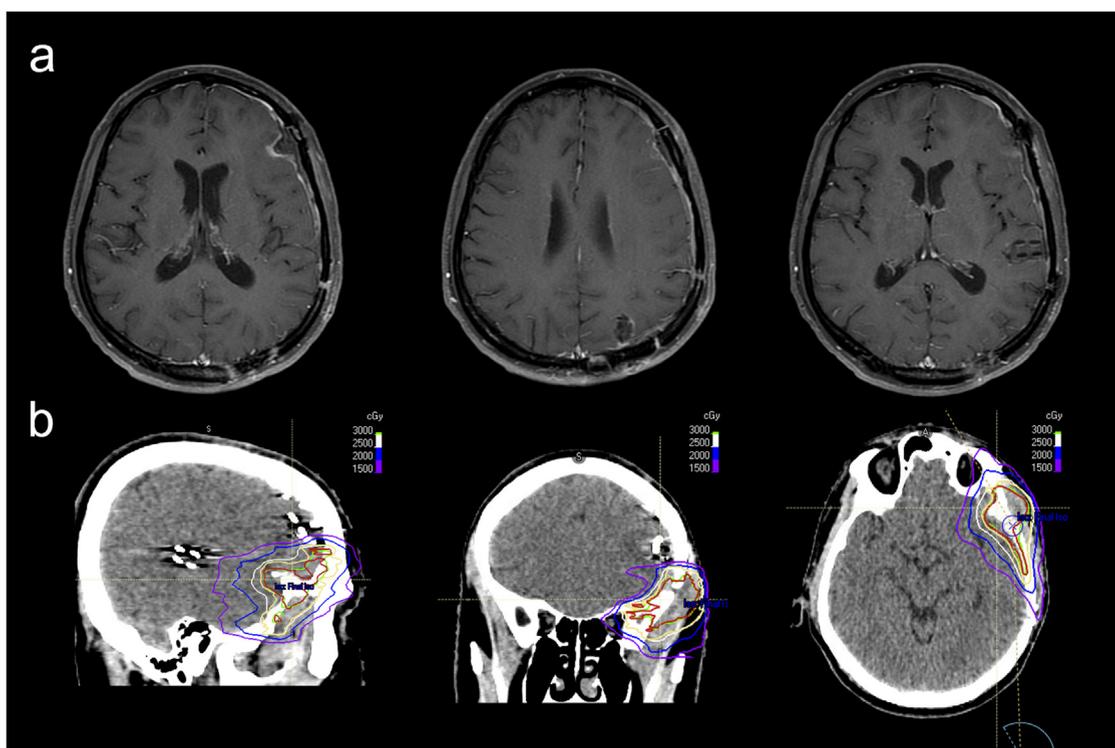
Left frontal dural recurrent and salvage stereotactic body radiation therapy. (a) Magnetic resonance imaging T1 +C 4.5 months postoperative demonstrating dural recurrence of the frontal lesion (left) with appropriate control at parietal (middle) and temporal (right) locations. (b) Sagittal (left) coronal (middle) and axial (right) noncontrasted computed tomography scans demonstrating salvage stereotactic body radiation therapy after marginal failure at the left frontal dura. This was treated in 5 fractions with 30 Gy prescribed to the gross tumor volume (red) and 25 Gy to a clinical target volume along the dura (yellow).
